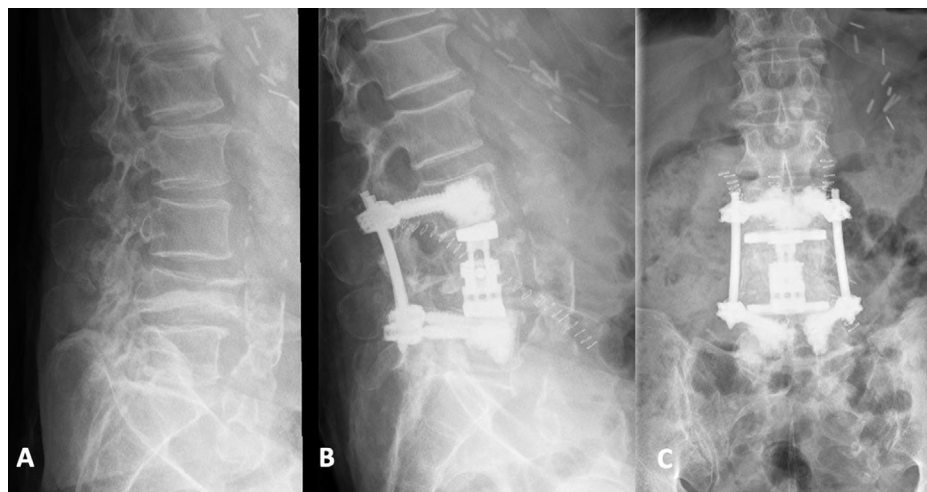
Vertebral body replacement L4. (A) Pathological L4 fracture due to metastatic bronchial carcinoma. (B) Lateral X-ray following short segment fixation with cement augmented pedicle screws and VBR with endplate cementation. (C) Anteroposterior view.
